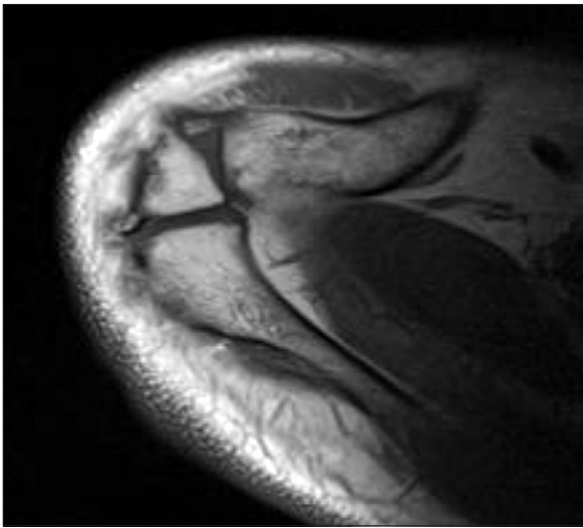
The fusion defect was seen on the axial T1 magnetic resonance image.
